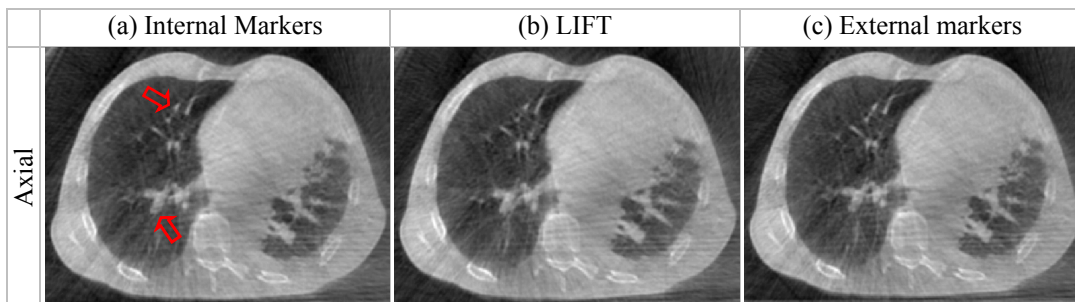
4D-CBCT Reconstruction from projection of Patient 4 in two different phases
